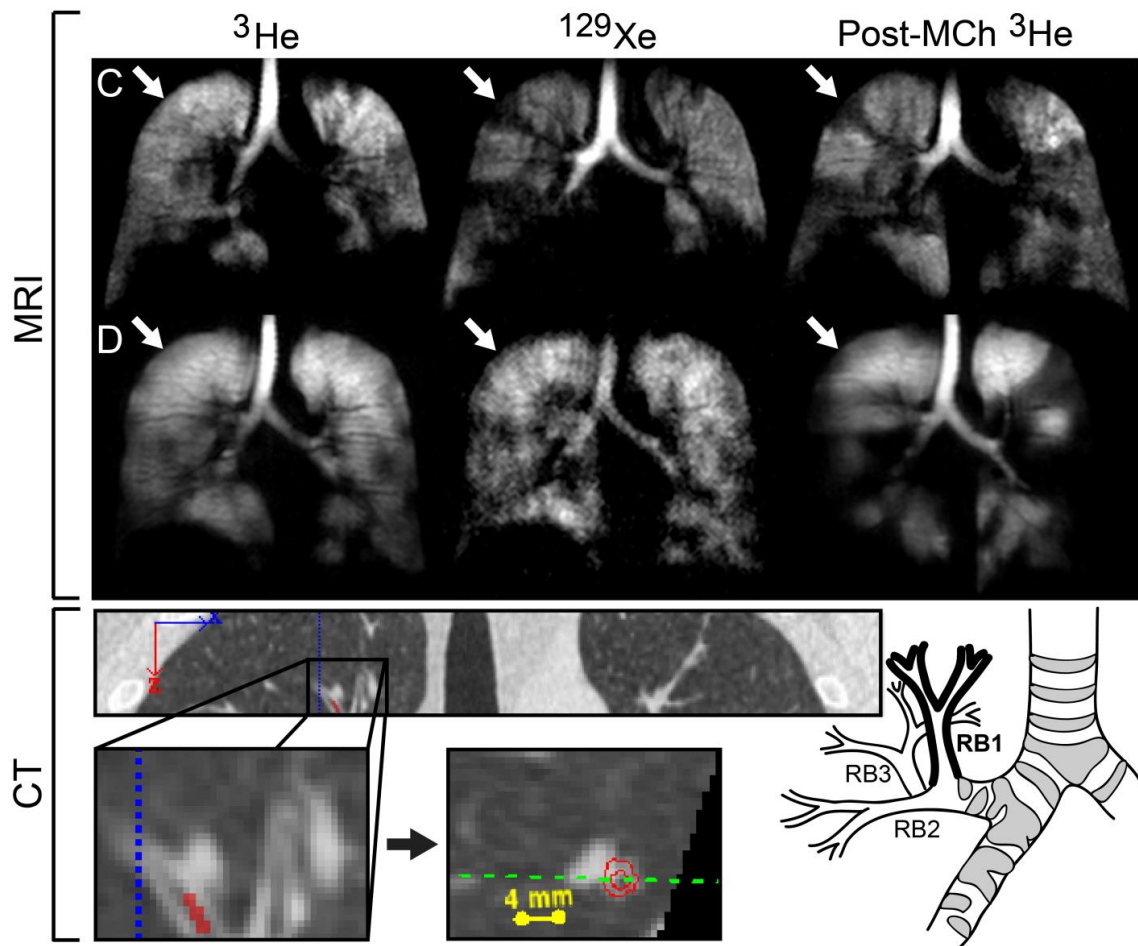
MRI and CT for two asthmatic subjects.
